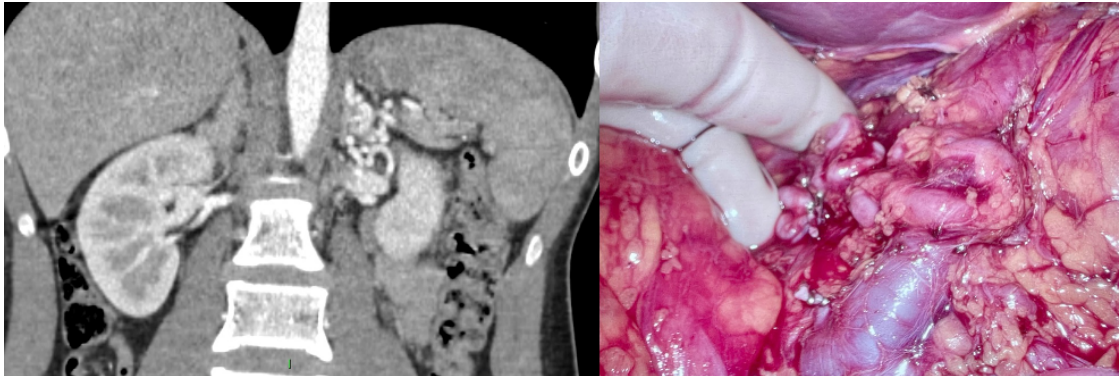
Coronal image of pre-operative computed tomography scan (left) and intraoperative imaging demonstrating the neovascular collaterals evident (right).
